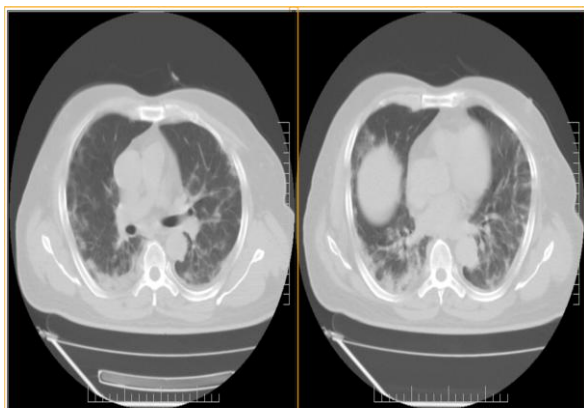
HRCT chest of COVID 19 patient in early phase shows presence of peripheral Ground glass opacities predominant in lower lobes.
